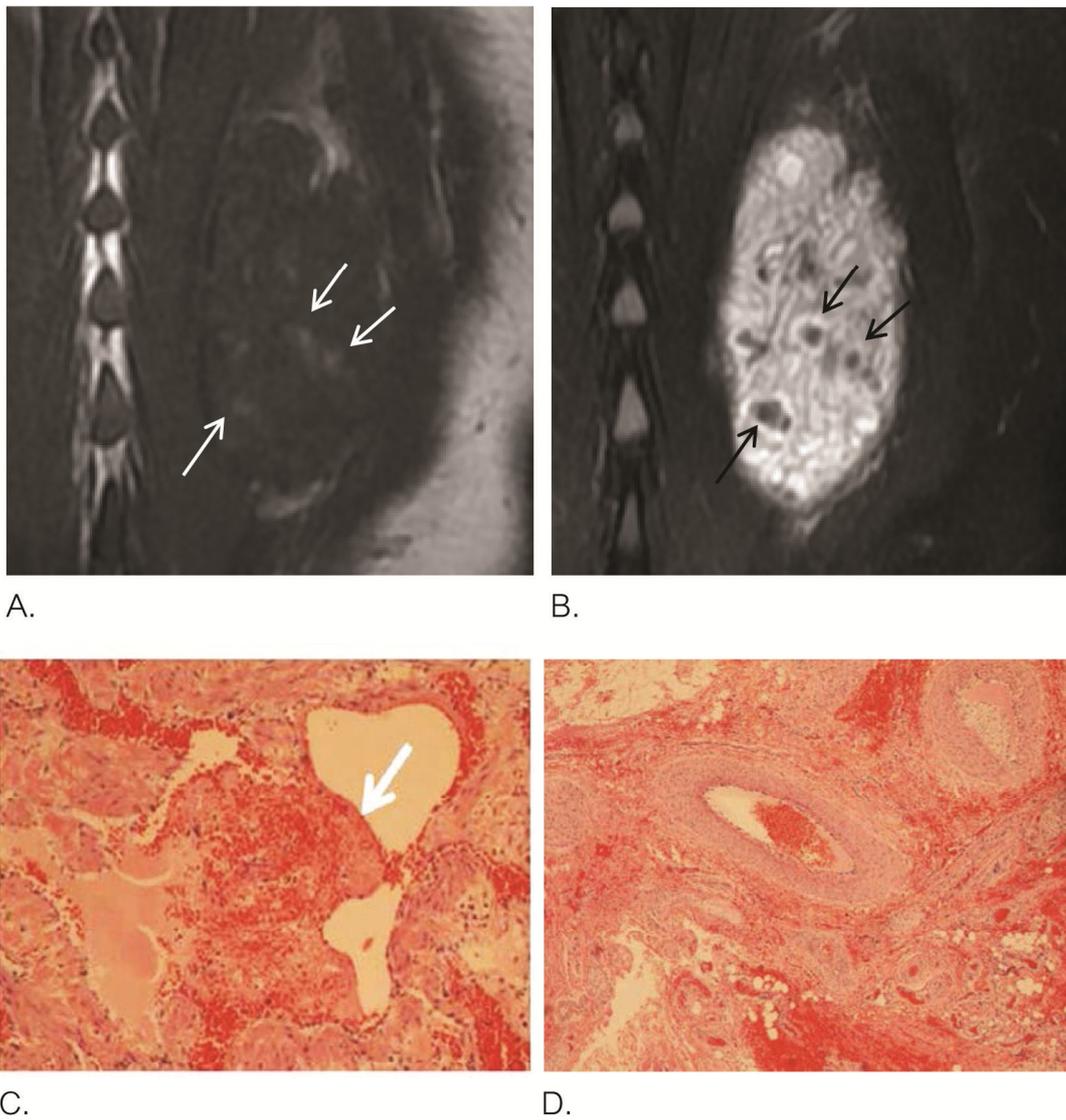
MR imaging of the back of a 1-year old boy. Multiple foci of hyperintense areas (white thin arrows) on coronal T1-weighted image A.) and hypointense areas (black thin arrows) on coronal T2-weighted image B.), which corresponded to intraluminal thrombi (arrow) on pathologic examination C.). D.) The pathological diagnosis is AVM.
